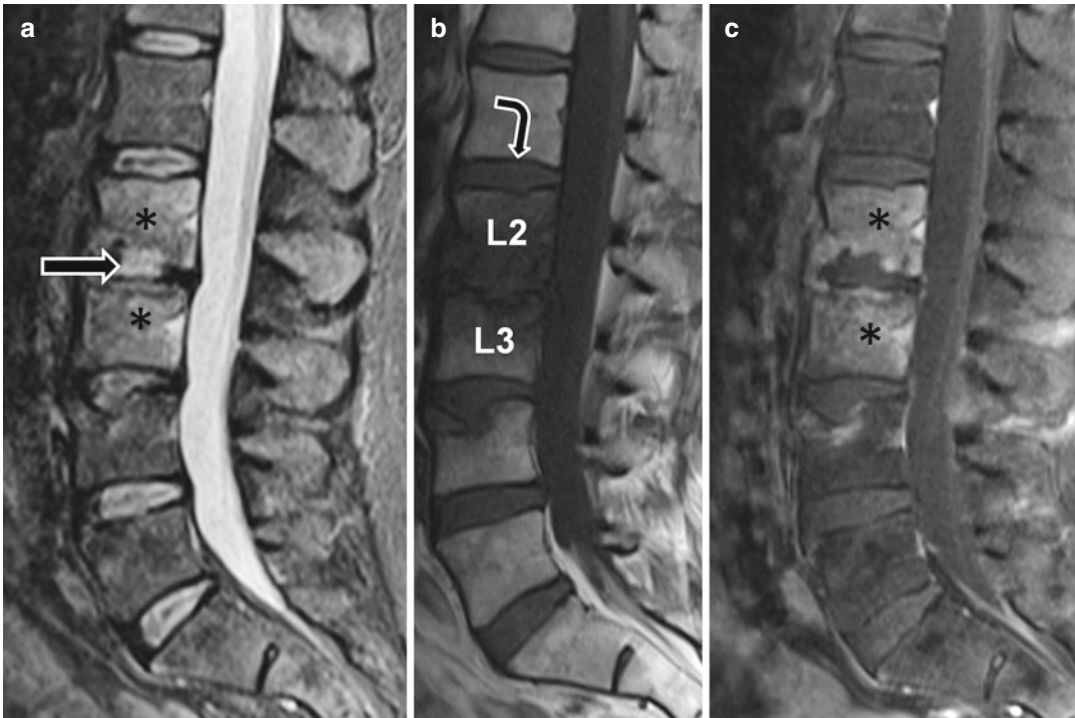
Same patient as in Fig. 4.24 with MRI confirmation of spondylodiskitis. (a) Sagittal short-tau inversion-recovery (STIR) MR image demonstrates fluid within the disk space (white arrow) as well as adjacent marrow edema (asterisk). Sagittal T1 (b) and T1 fat-saturated
